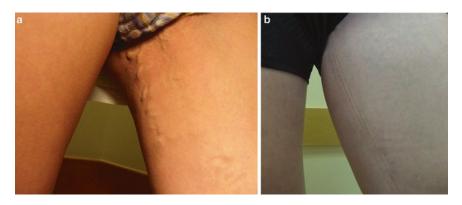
Pelvic source varicose veins before and 3 months after ultrasound-guided foam sclerotherapy. (a) Baseline. (b) Three months
